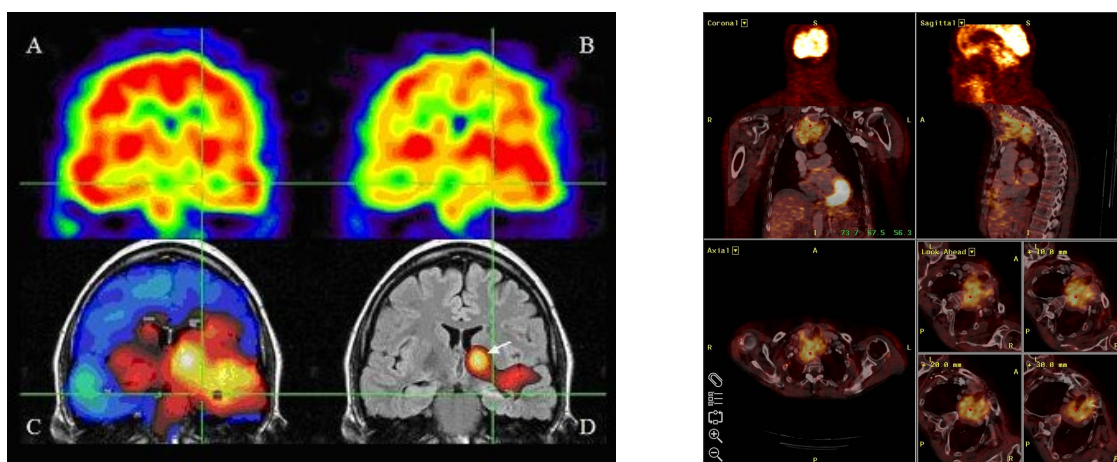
SPECT image of the brain (left) and a PET of the upper part of the body (right). Both imaging modalities are fused with a CT image of the respective regions.
